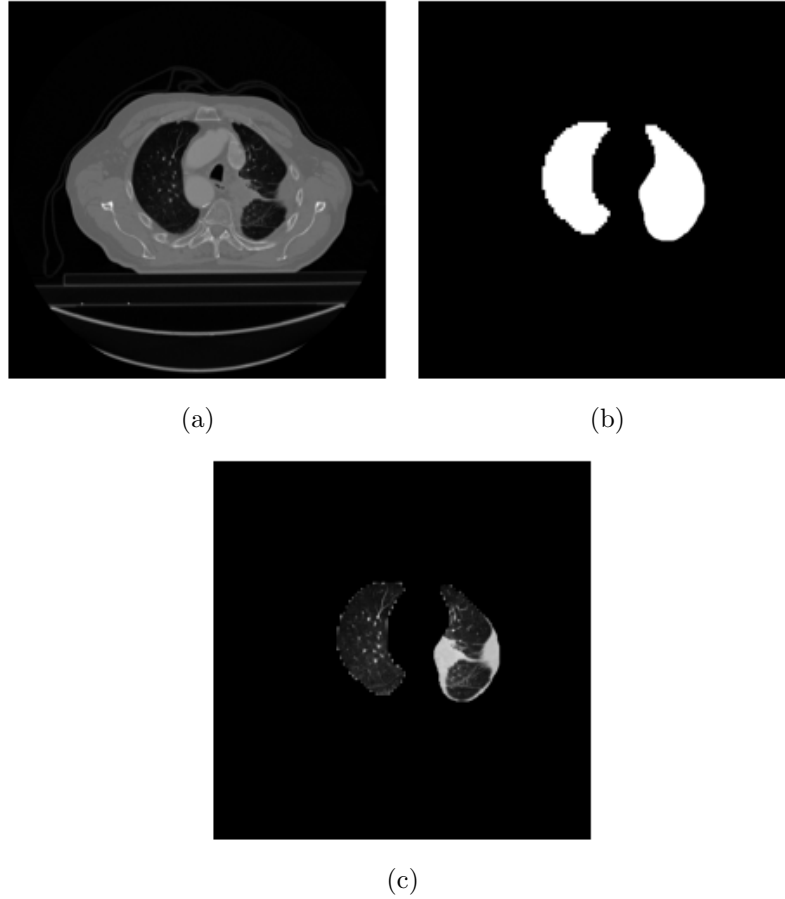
(a) Original CT Slice (b) Original Mask (c) Masked lung
